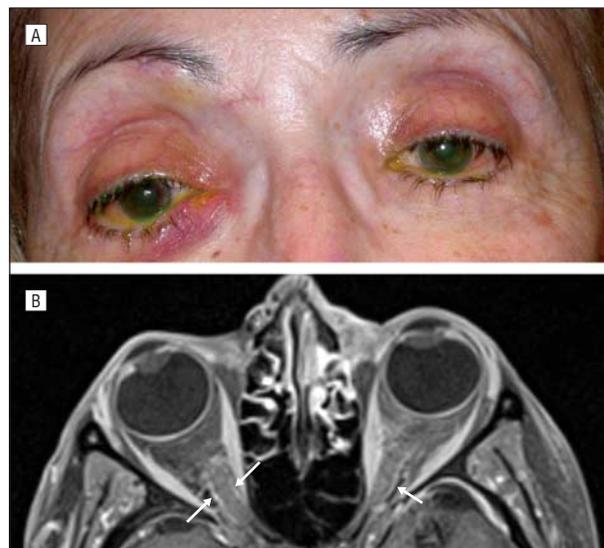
Clinical photograph demonstrating 2 firm, nontender subcutaneous masses below the medial end of the right eyebrow with right lower eyelid erythema (A), and an axial T1-weighted magnetic resonance image of the orbit with gadolinium infusion and fat suppression showing smooth perineural enhancement of both intraorbital optic nerve sheaths (arrows) (B).
